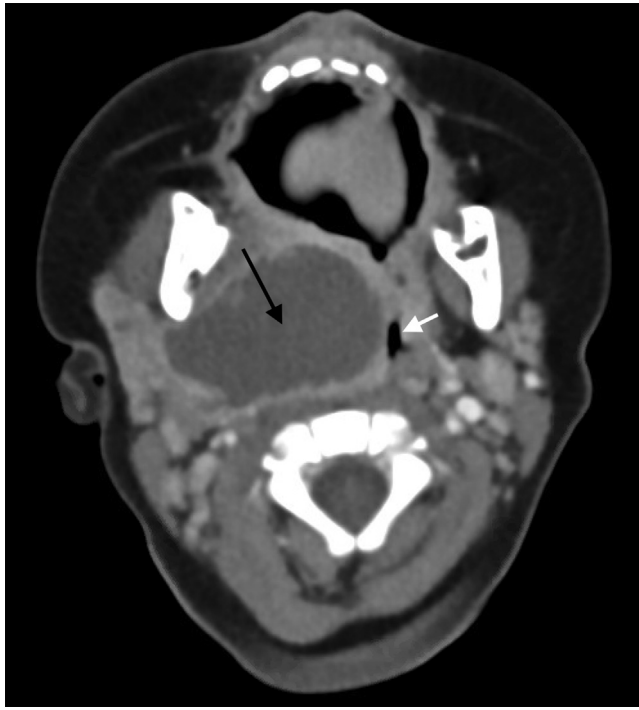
Axial computed tomography of the neck showing a 4-cm right peritonsillar abscess (black arrow) with significant mass effect and compression of the airway (white arrow)
